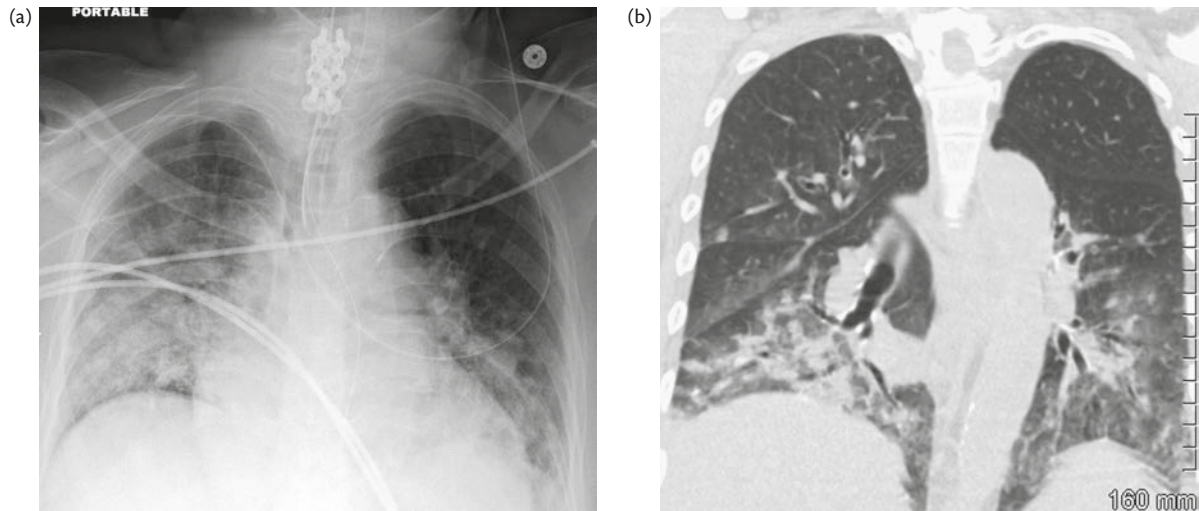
Case 2. (a) X-ray; (b) CT scan.
